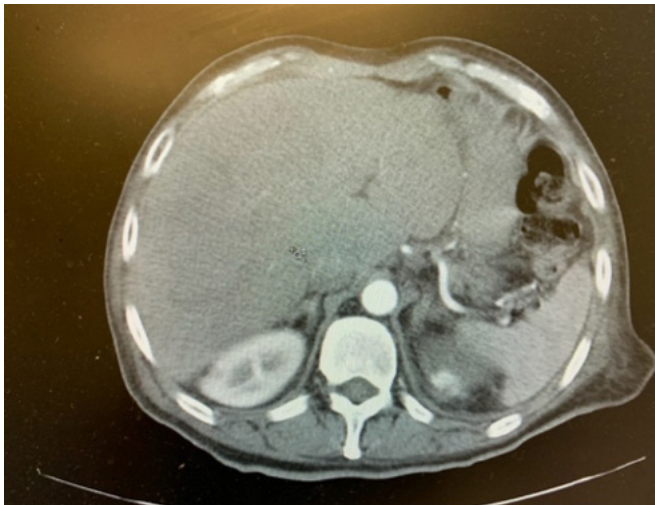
Post-Intervention CT Demonstrating Hepatic Abscess and Drain Placement. Published with Permission.
